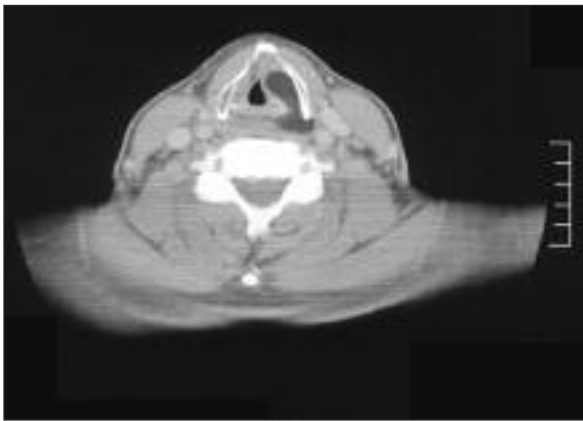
The lipoma extending from left vocal cord to posterior commissure is seen on axial CT image.
